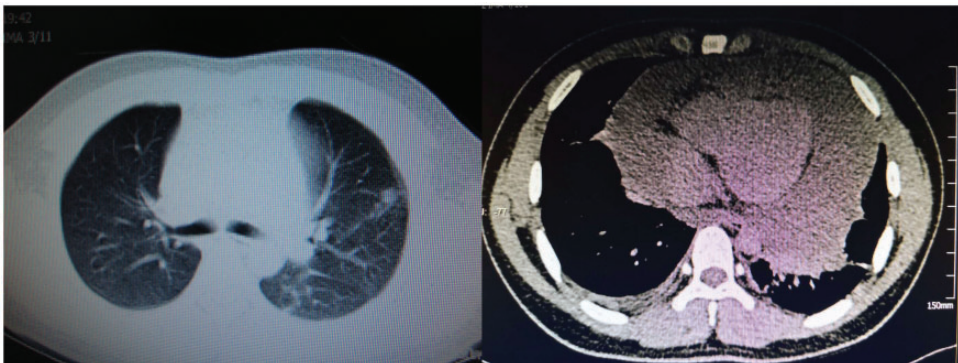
Computed tomographic scan of the chest. A small high-density shadow in the left upper lung field near the pleura in a lung window image and a large amount of pericardial effusion with a small amount of pleural effusion in a mediastinal window image can be seen.
